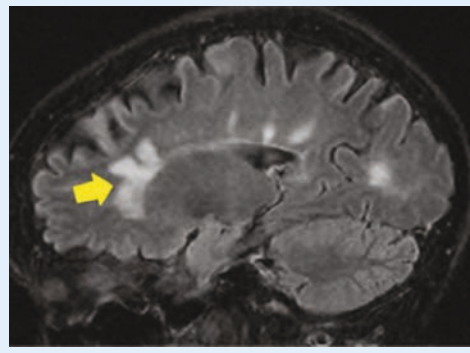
Sagittal fluid-attenuation inversion recovery image obtained at conventional MRI for a patient with multiple sclerosis demonstrates hyperintense lesions (arrow) but cannot distinguish between axonal injury and demyelination.
